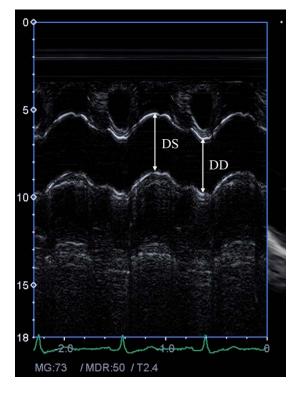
Measurement of systolic (DS) and diastolic (DD) diameters of the ascending aorta are shown on the M-mode tracing obtained at a level 3 cm above the aortic valve at parasternal long-axis view
